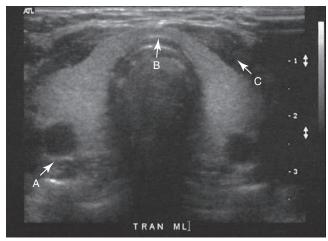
Transverse sonogram of the midline neck.
